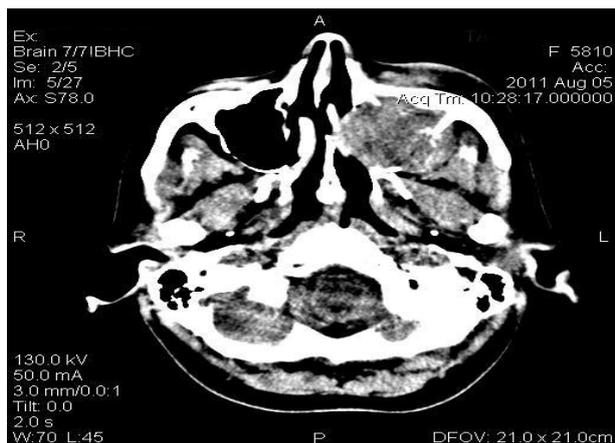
Axial CT image shows a homogenous tumoral mass situated into the left maxillary sinus that invaded the nasal cavity (Costea *et al.*,2015).
